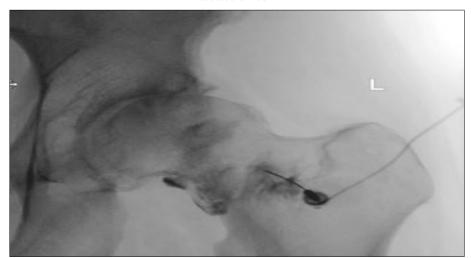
Anteroposterior (AP) view of left hip in 2021 during fluoroscopic guided joint injection. Radiographs demonstrate mild to moderate superior joint space narrowing with mild sclerosis in the superior acetabulum. No significant osteophytes, erosions, or abnormal bone lesions.
